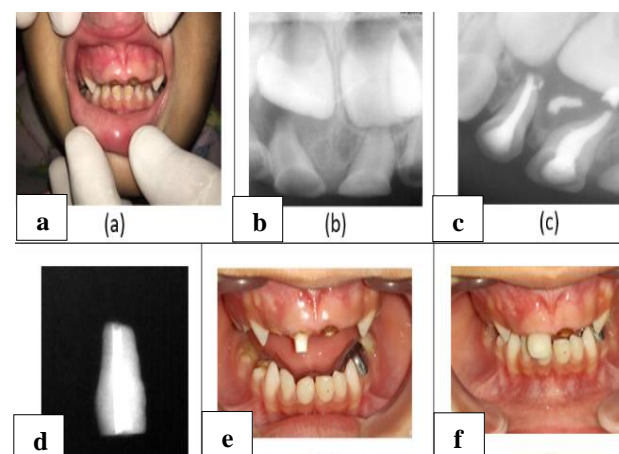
Biological restoration as a post and core (a-f): (a) preoperative picture; (b) preoperative radiograph; (c) pulpectomy performed w.r.t 51; (d) biological post preparation; (e) biological post cementation w.r.t 51; (f) and post-operative strip crown restoration w.r.t 51.
